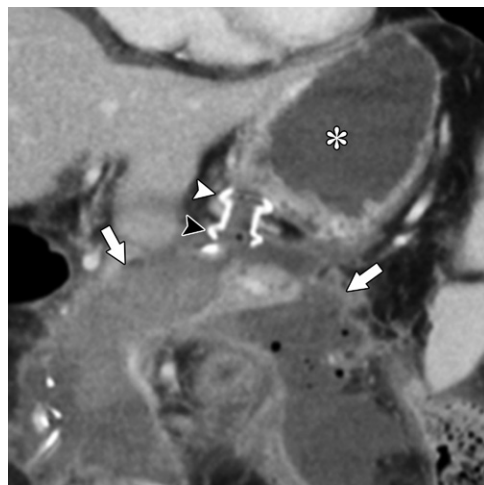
LAMS migration and buried-stent syndrome in a 59-year-old man with WON. Coronal contrast-enhanced CT image obtained 3 weeks after cystogastrostomy with LAMS placement shows a distal flange (black arrowhead) in the collection (arrows) but a proximal flange (white arrowhead) displaced from the gastric lumen (*), buried beneath the gastric wall.
